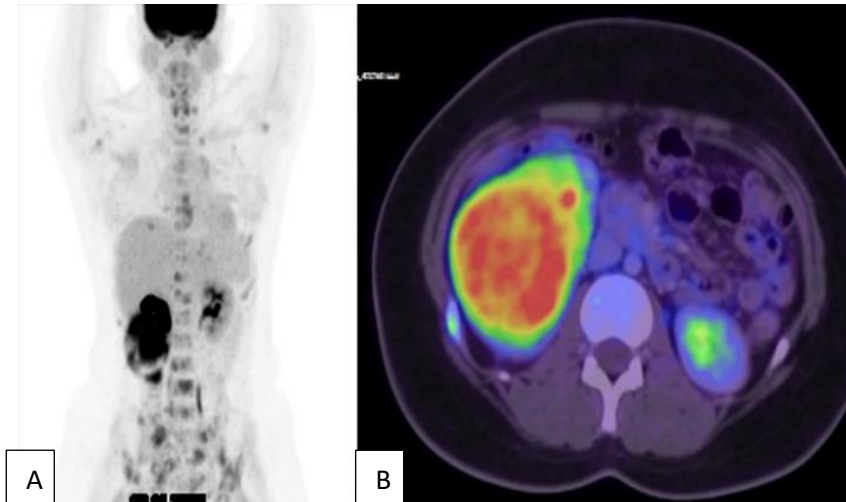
(A) PET-CT coronal view showing multiple FDG avid lesions in the lower pole of right kidney, axial and appendicular skeleton; (B) PET-CT axial view with FDG Avid mass lesion (11.6×7.5×7.1 cm; SUV max: 13.09) in the interpolar and lower pole of the right kidney.
